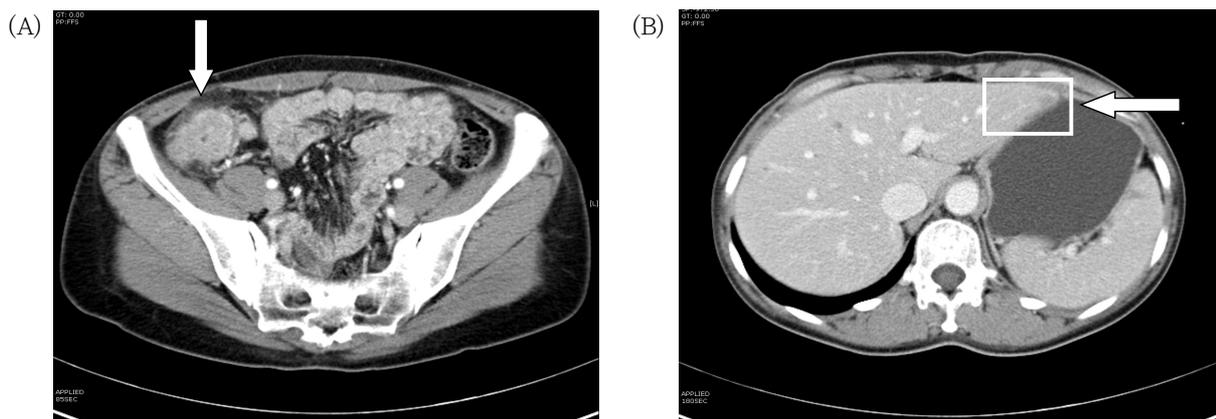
Abdominal CT scan showed wall thickening of the cecum (A), and metastatic nodule in the left lobe of liver (B)
